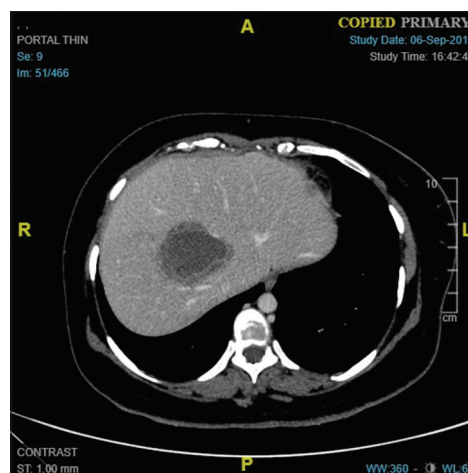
Computed tomography (CT) multiphase study shows a solitary well-defined roundish hypodense lesion with thin peripheral smooth enhancing wall with a surrounding rim of edema measuring 47 × 41 × 39 mm in segment VIII of liver consistent with liver abscess
